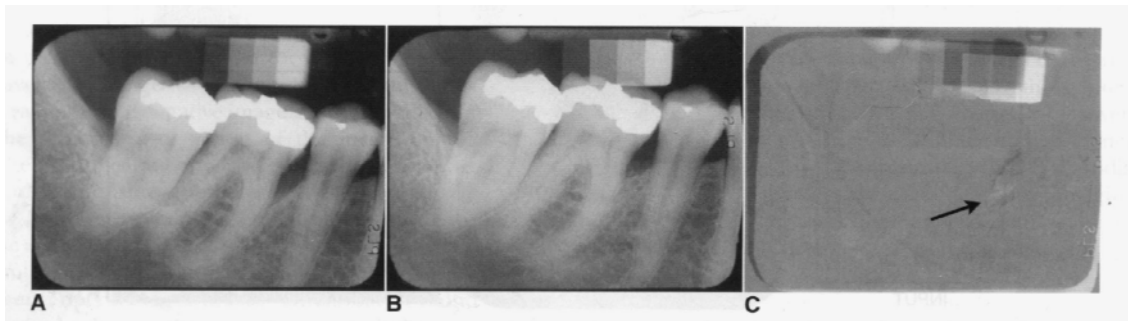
Application of digital subtraction radiography for detection and quantification of periodontal bone healing. A, Base line image. B, Standardized 1-year follow-up image. C, Subtraction image showing increase in bone(arrow).
